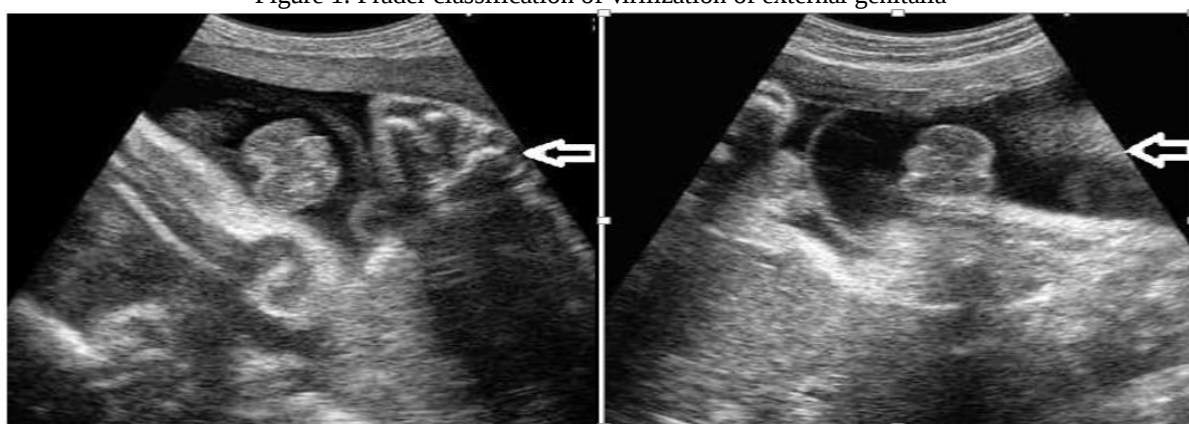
Ultrasonographic appearance of external genitalia
